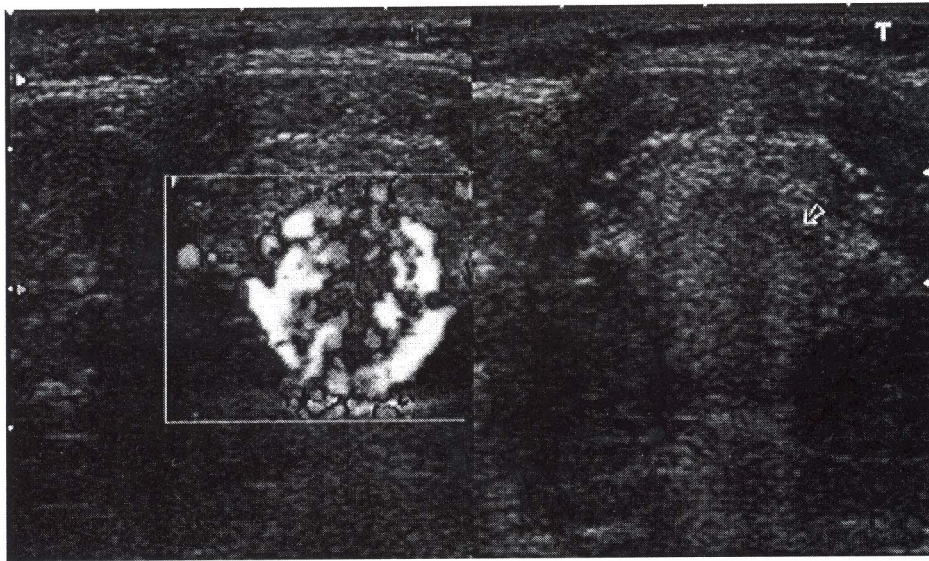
Ultrasound with colour Doppler of one patient with sublingual thyroid
